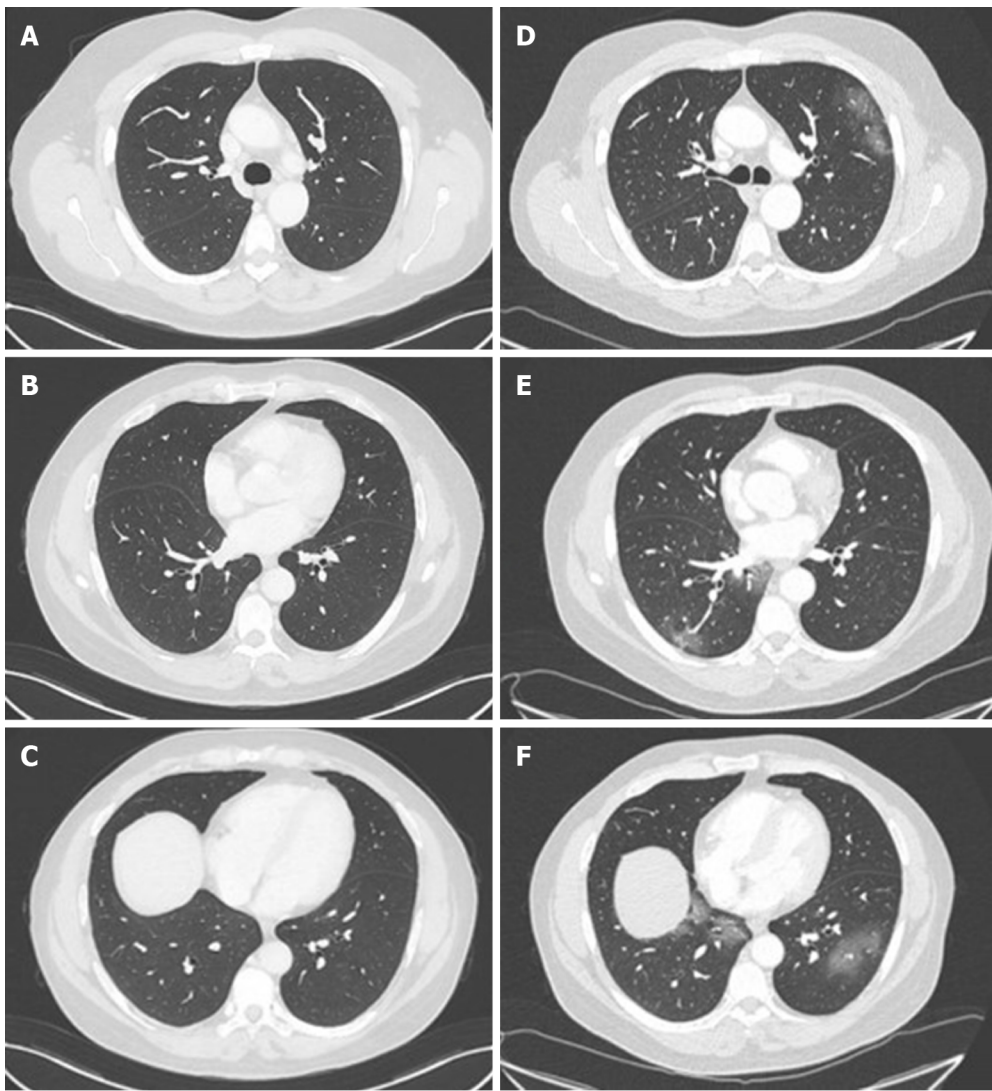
Chest computed tomography of a 58-year-old man who underwent liver transplantation in 2018. A-C: Normal chest computed tomography (CT) of the patient in November 2019; D and E: Chest CT on admission in March 2020 showing ground-glass opacities with a peripheral distribution.
